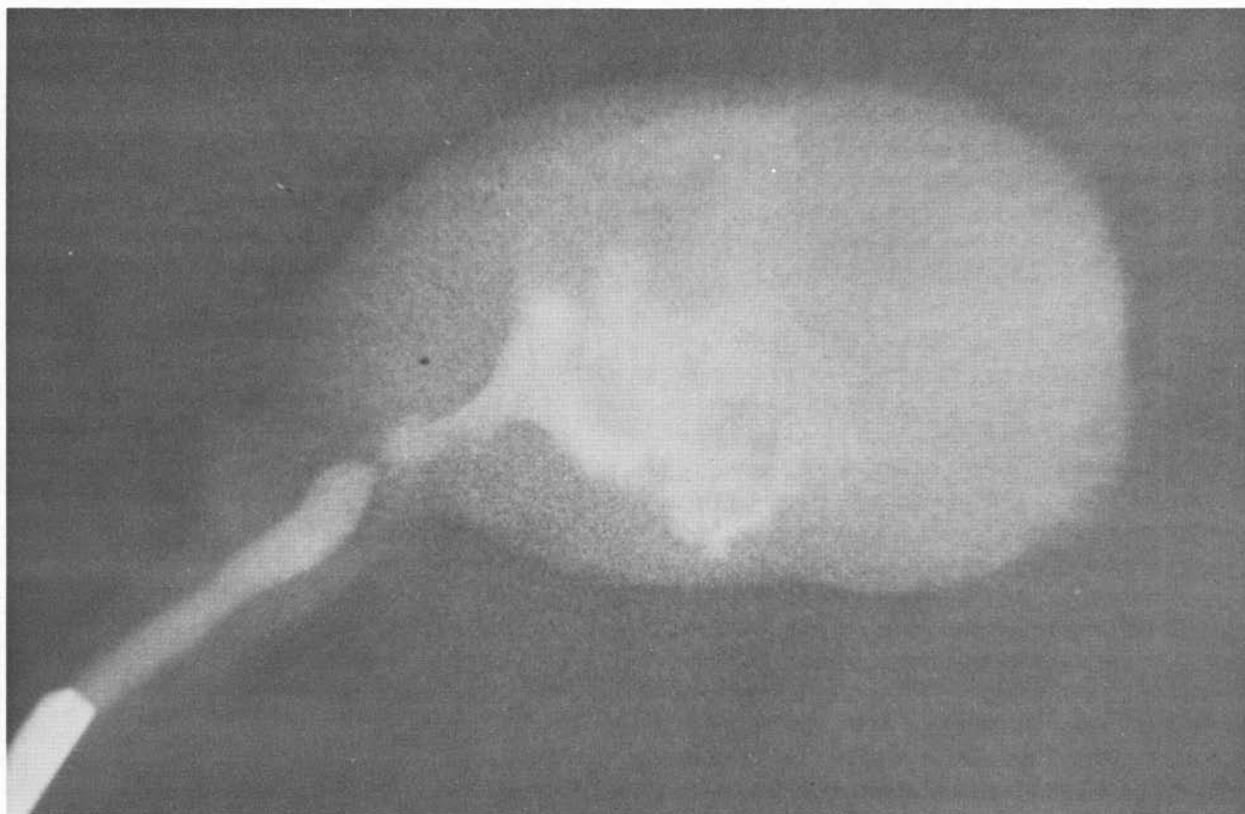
Injection x-ray of a cystic spermatic granuloma. The vas is on the left.
